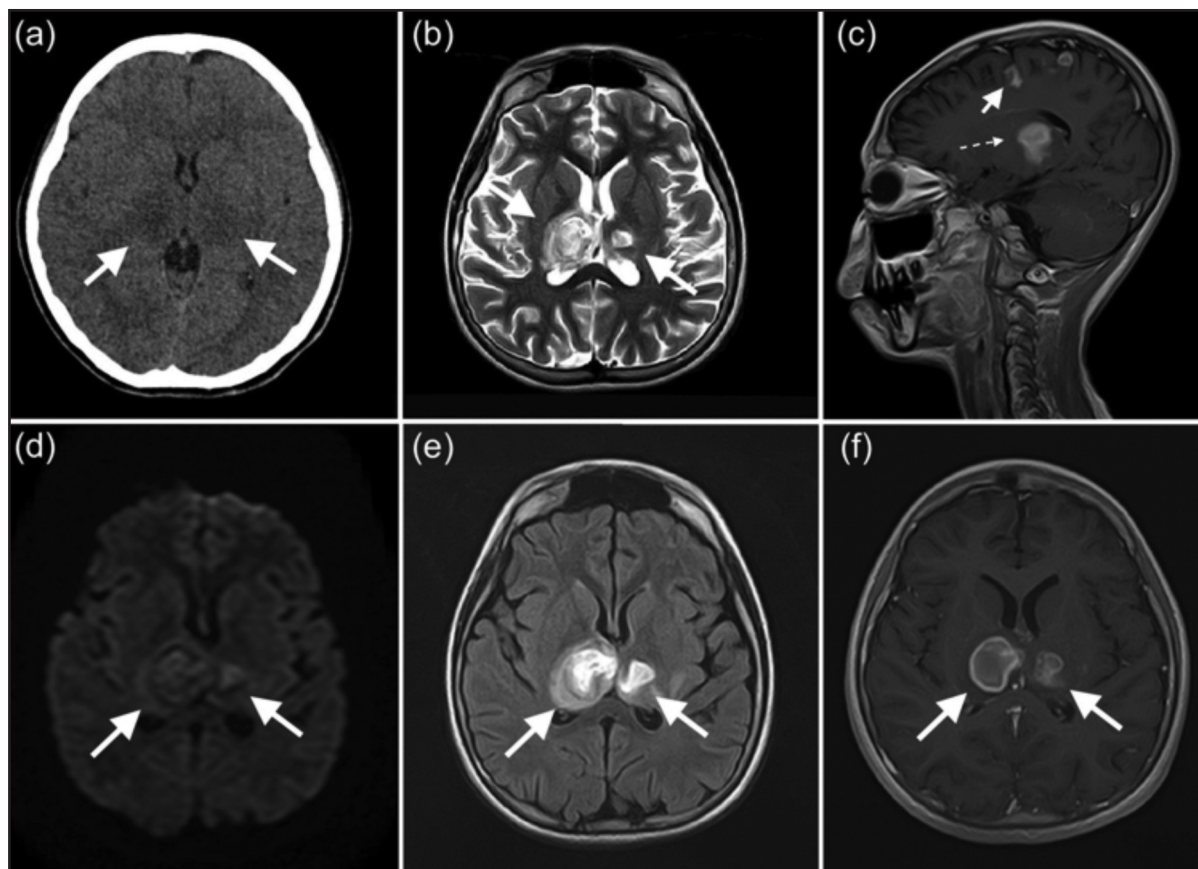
Selected MR and CT images acquired prior to treatment. (a) Axial unenhanced CT brain shows ill-defined bithalamic hypodensities extending to the posterior limbs of internal capsule. (b) Axial T2 weighted MR brain images shows bithalamic high signal. (c) Post-gadolinium T1 weighted MR images demonstrate rim-enhancing lesions at the grey-white matter junction of the right frontal lobe. One of the lesions demonstrates an incomplete ring configuration (white arrow). (d) Diffusion weighted MR image shows absence of restricted diffusion. (e) FLAIR MR brain images shows bithalamic high signal. (f) Post-gadolinium T1 weighted MR images demonstrate rim-enhancing lesions at thalamus.
